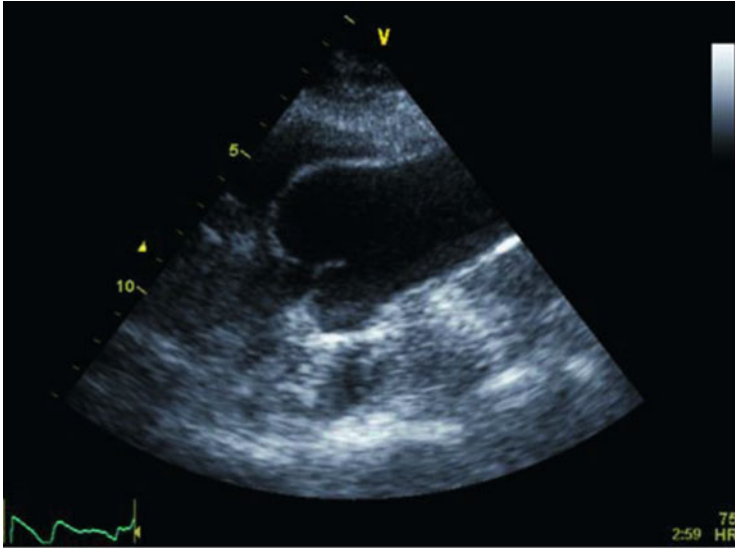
Long-axis echocardiography showing a dilated aortic root in a patient with Marfan syndrome (From Mulder [4])
